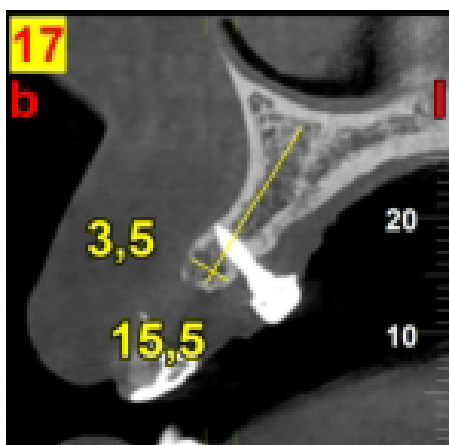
Sagittal cone-beam section at 5 year follow-up.
